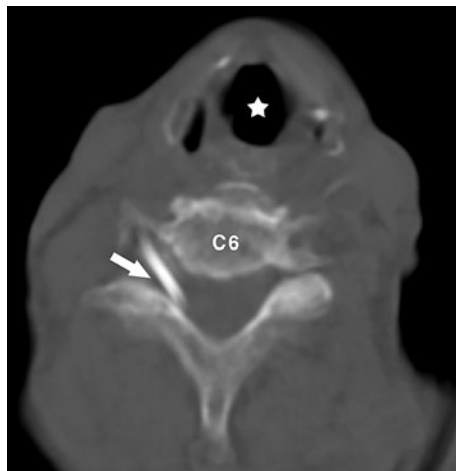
Axial computed tomography of the neck shows catheter passing through the right neuroforamen C6–C7 (arrow). Star trachea
